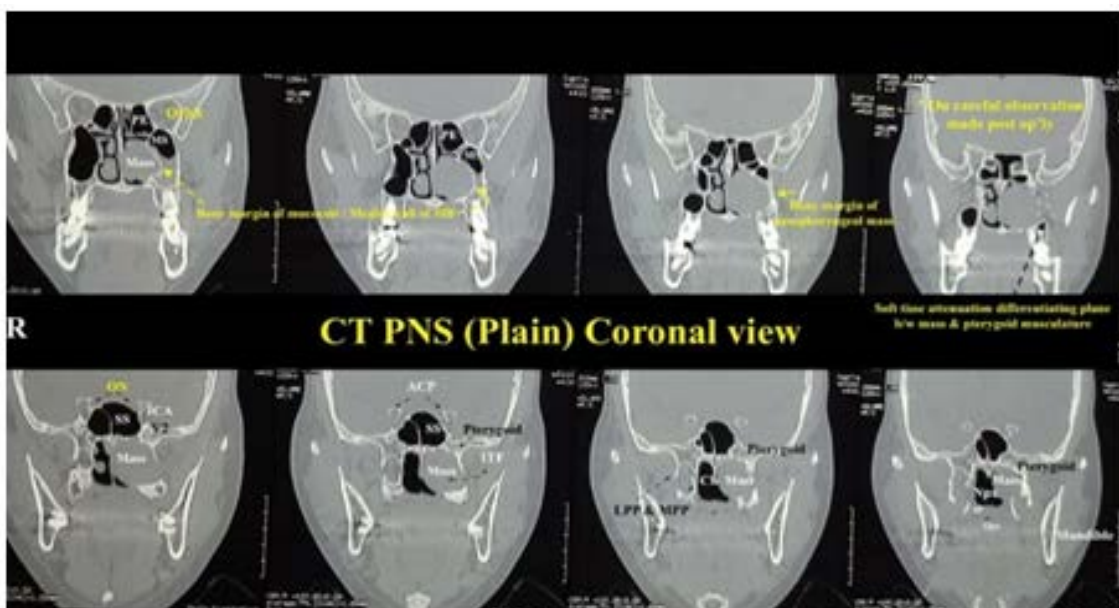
CT scanned image of para coronal view of nose.
